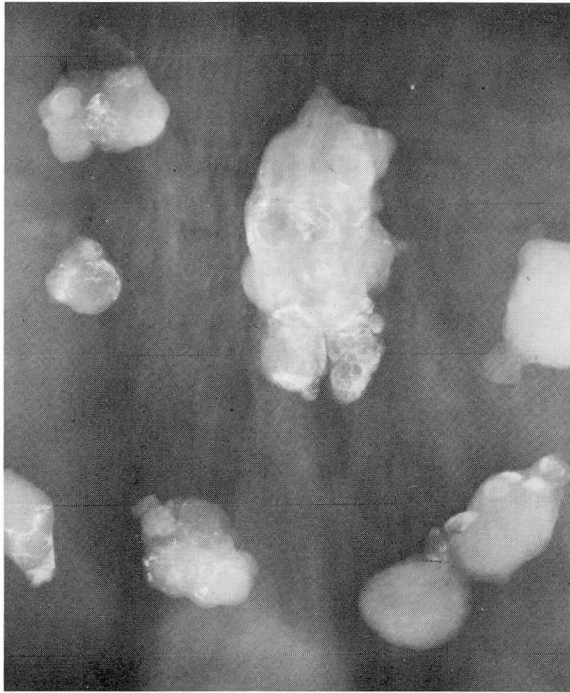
Case 1. Roentgenogram of excised nodes showing that they contain only small amounts of contrast material because they were almost totally replaced by tumor.
